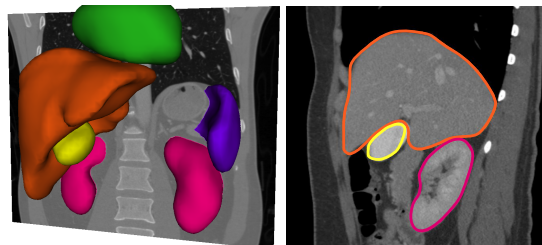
Results of fine segmentation given by our method on two CT images, 3D rendering on the left and sagittal slice on the right (liver, kidneys, spleen, gallbladder and heart).
